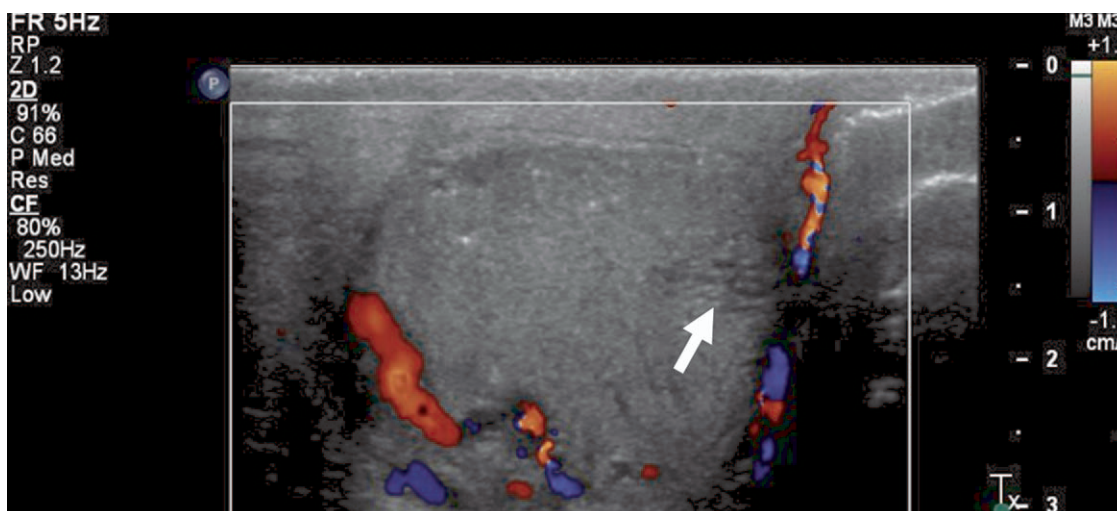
Transverse color Doppler sonogram of the left testis demonstrates anechoic tubular structures near the testicular mediastinum (arrow). These demonstrate no flow, consistent with tubular ectasia of the rete testis.
